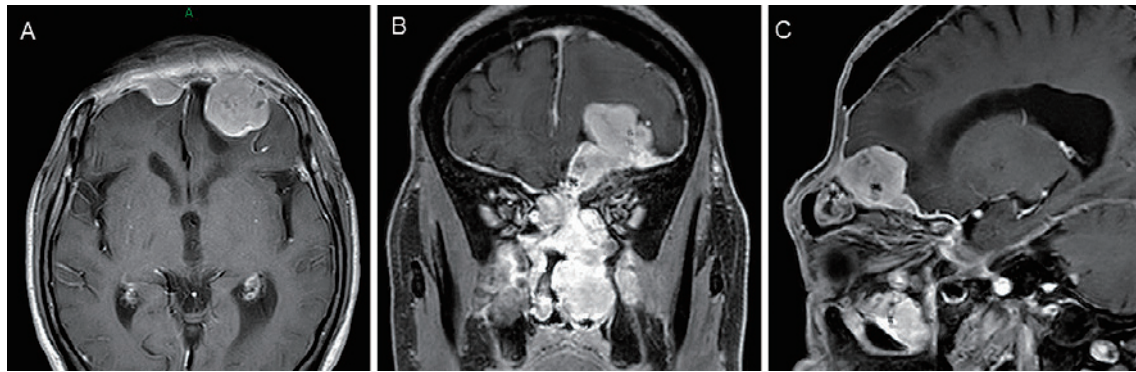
Preoperative post-gadolinium enhanced MRI.
